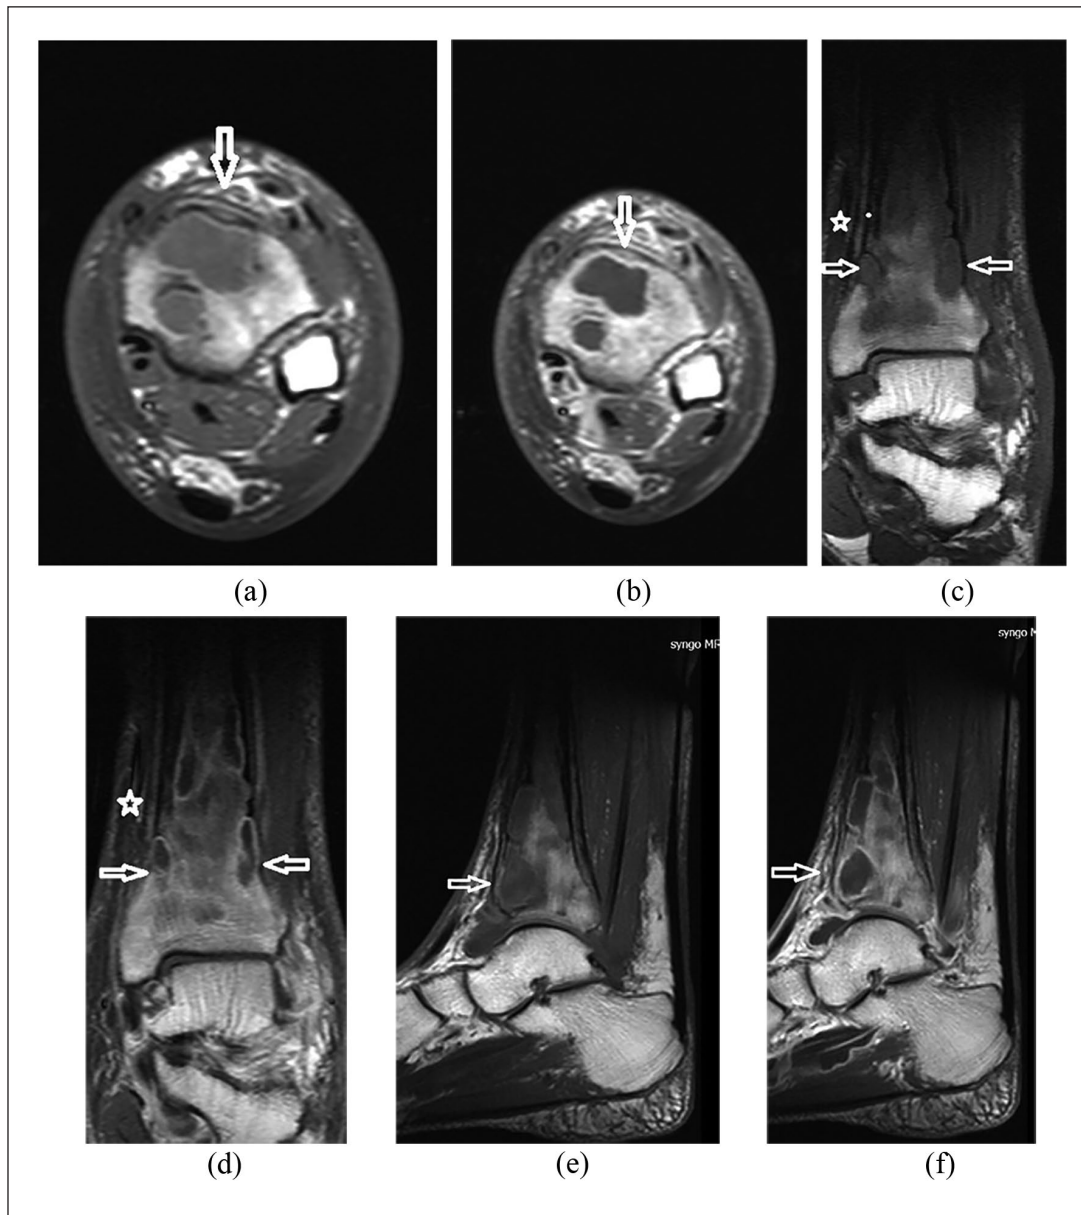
(a)–(f) T1-weighted pre- and post-contrast images on the axial, coronal and sagittal planes. Multiple hypointense lesions causing an expansion in the intramedullary region are observed (arrows). Peripheral enhancement like abscess lesions is noteworthy in post-contrast series (arrows). (c) and (d) The heterogeneous contrast in the soft tissue was considered as inflammation and edema (stars).
